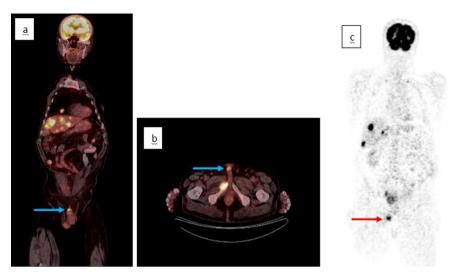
PET/CT Imaging(post-chemotherapy). (a) The coronal ¹⁸FDG-PET/CT scans show, (arrow: penile metastasis, 12 mm), SUV_{max}: 9.0. (b) The axial ¹⁸FDG-PET/CT scans show, (arrow: penile metastasis, 12 mm) SUV_{max}: 9.0. (c) Maximum intensity projection (MIP) images, (arrow: penile metastasis).
